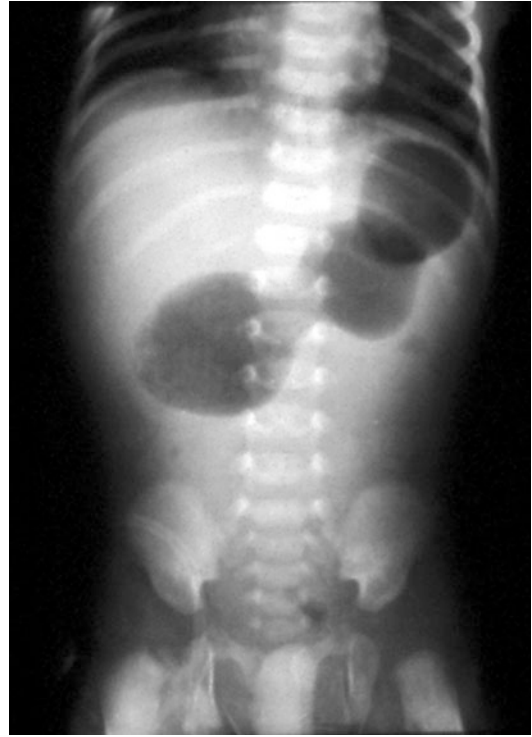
Abdominal plain film in newborn with HPS shows a large distended stomach by air with few amount of distal gas pattern
